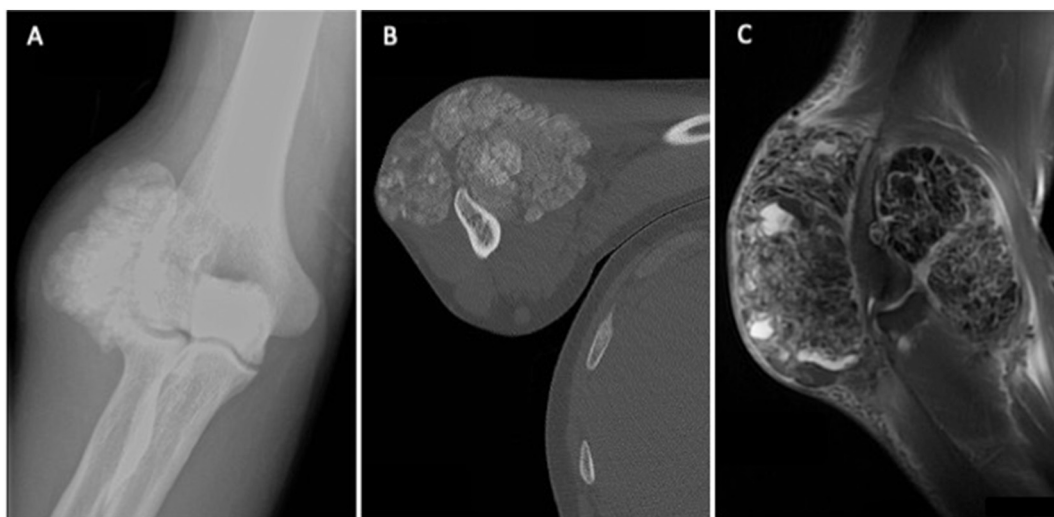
A. En-face view X-rays of the right elbow with periarticular calcifications. B. CT-scan of the right elbow objectived two calcified masses (anterior and lateral) C. MRI of the right elbow shows extrinsic compression of the deep branch of the radial nerve against the humerus by the anterior masse.
